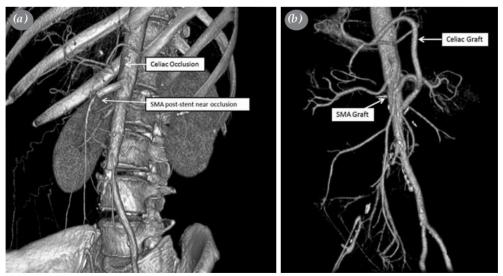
(a) A preoperative computed tomography scan of the patient with chronic mesenteric ischemia with previous superior mesenteric artery stenting. (b) A postoperative fourth month computed tomography scan of the patient. The Dacron graft of superior mesenteric artery and celiac arteries are patent.
